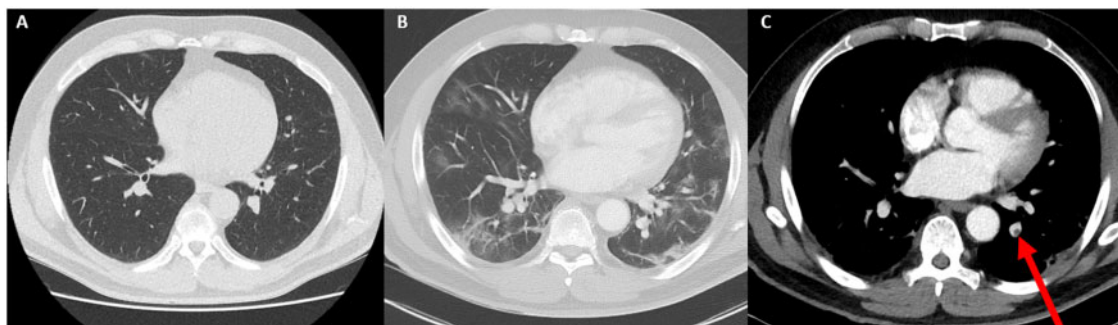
Serial chest computed tomography scans of Patient 2. (A) Low dose computed tomography scan on the first hospitalization showing normal lung parenchyma. (B) High resolution computed tomography scan (lung window) on readmission showing multiple subpleural ground-glass opacifications. (C) Computed tomography angiography showing filling defects (arrow) in the left inferior lobar artery branch.
